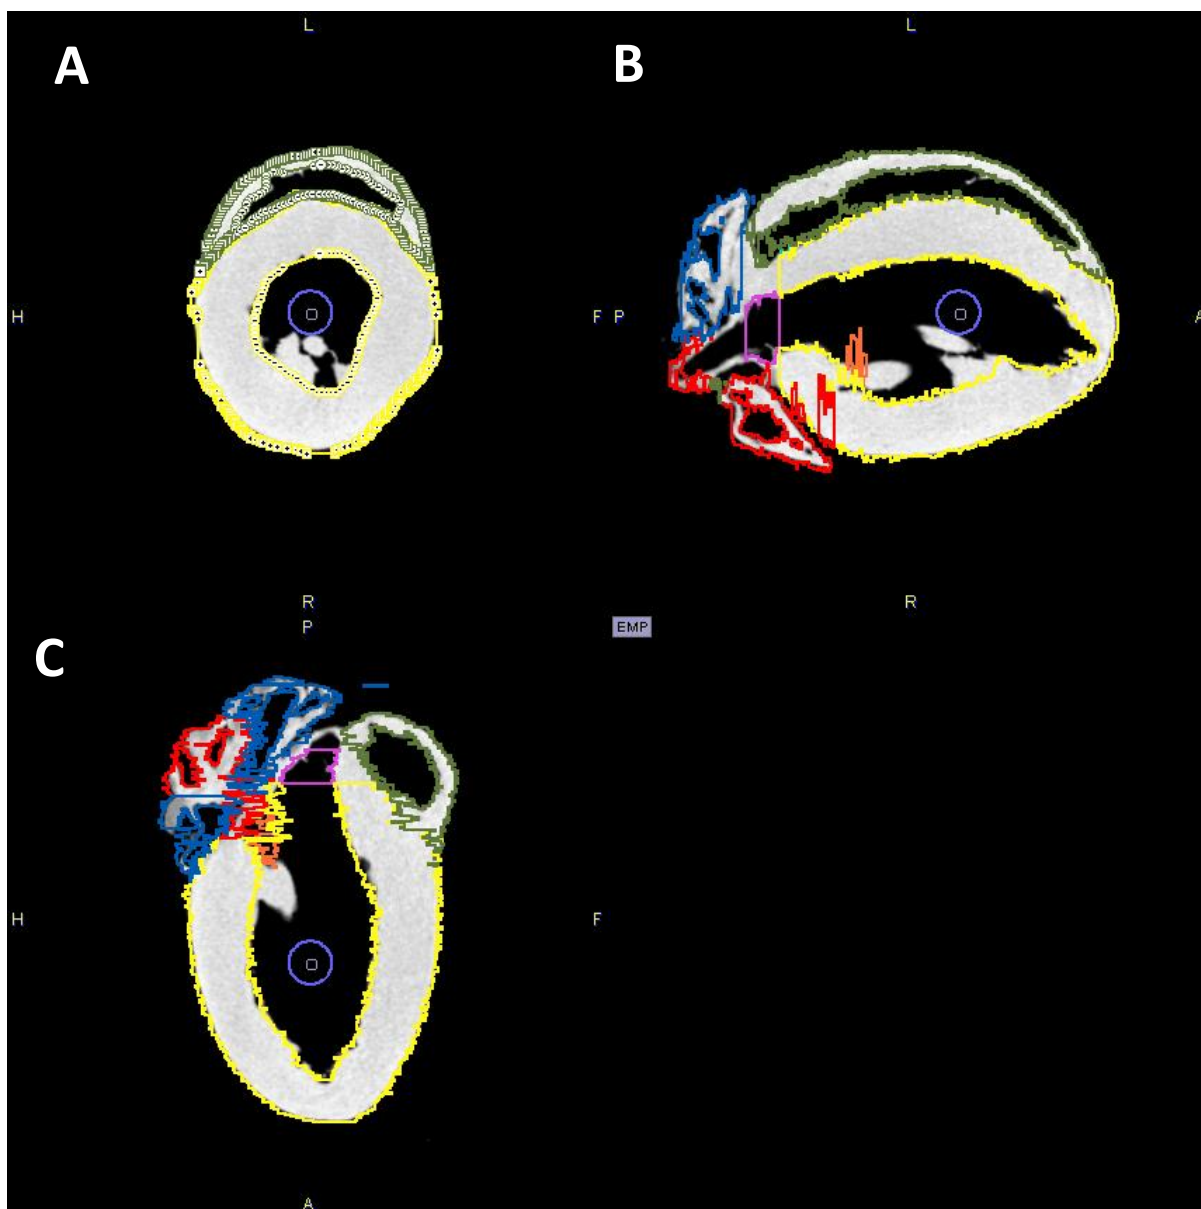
2 Representative image of high-resolution CT and cardiac VOI template. *Ex vivo* high-resolution CT imaging was carried out cadmium enhanced PFA perfused heart and VOIs are outlined based on this image. Image shows the VOIs in transverse (A), coronal (B) and sagittal (C) planes. Yellow: LV; Green: RV; Red: LA; Blue: RA; Blue Circle VOI: Blood pool; Purple: Valve.
